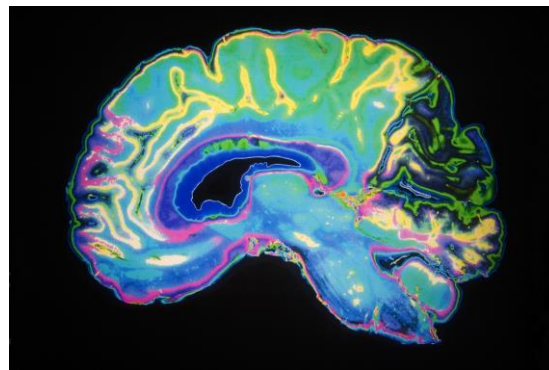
MRI of Adult Brain
